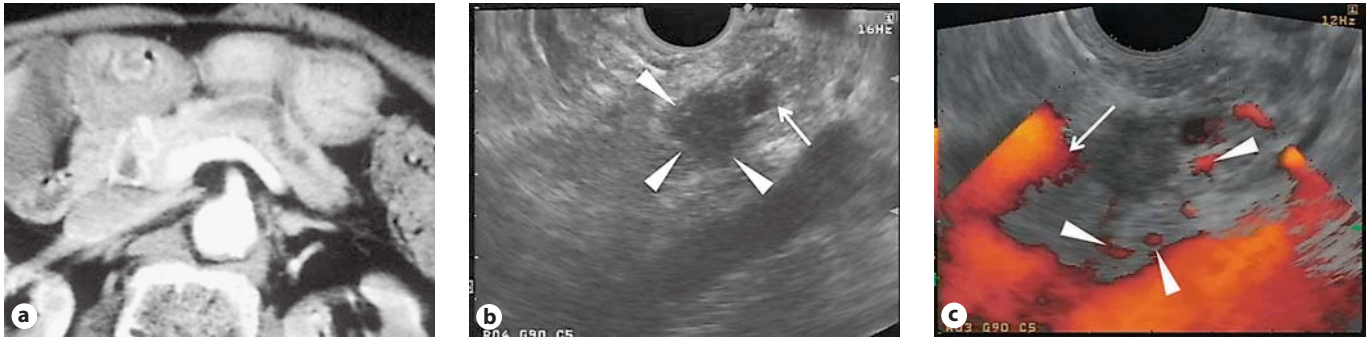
Typical MDCT, EUS, and contrast-enhanced power Doppler EUS images of a small ductal carcinoma. a The MDCT image shows the dilated duct in the body and tail of the pancreas, but fails to depict a nodule. b The conventional EUS image shows a hypoechoic nodule (arrowheads) 11 mm in diameter.
